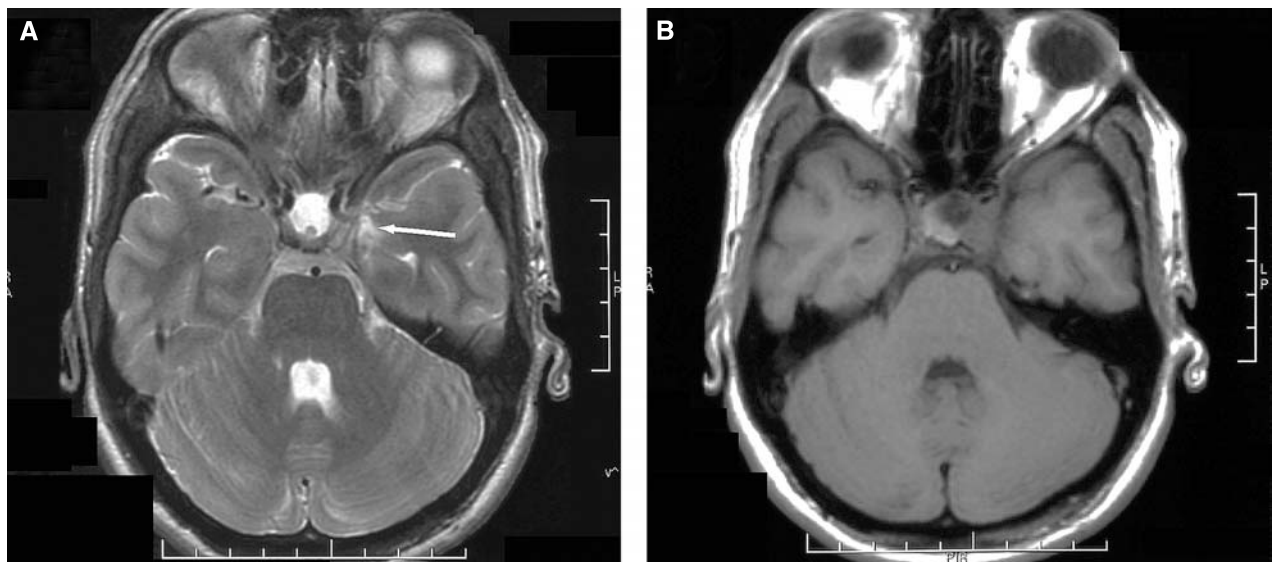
MR scan 25 months after gamma knife surgery. The T2-weighted image in A shows a regressive lesion in the left medial temporal lobe with only minimal remaining signal hyperintensity (arrow). The T1 weighted image in B reveals no structural changes in the left temporal lobe. The residual hypophyseal adenoma is reduced in size compared to earlier imaging studies
